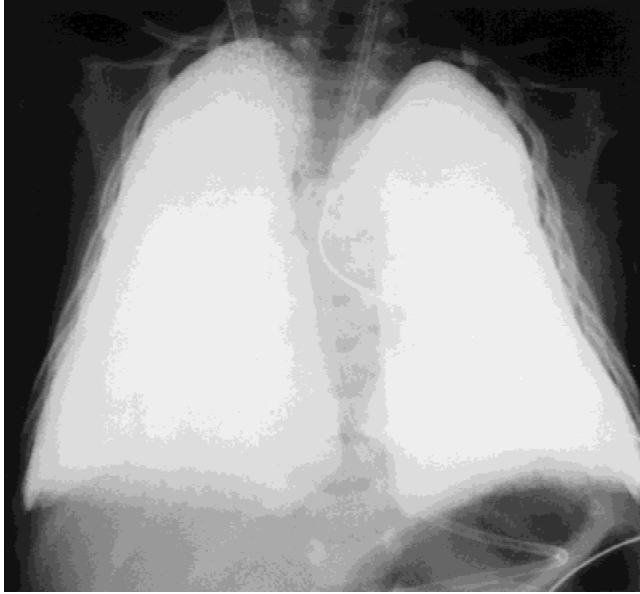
AP chest x-ray demonstrating the usual appearance of the radiopaque perflubron-filled lungs.
